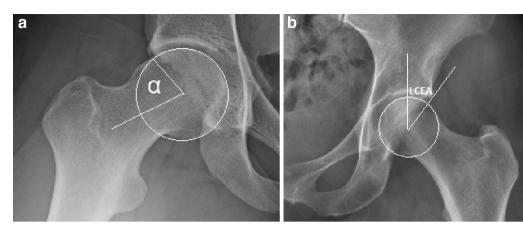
Diagnosis of FAI morphology. The a alpha angle and b lateral center edge angle are two of the imaging parameters commonly used to classify FAI morphology. The alpha angle (a), shown here on a modified Dunn X-ray view, is the angle formed by the femoral neck axis and a line connecting the center of the femoral head to the point at which the head–neck contour becomes aspherical.
